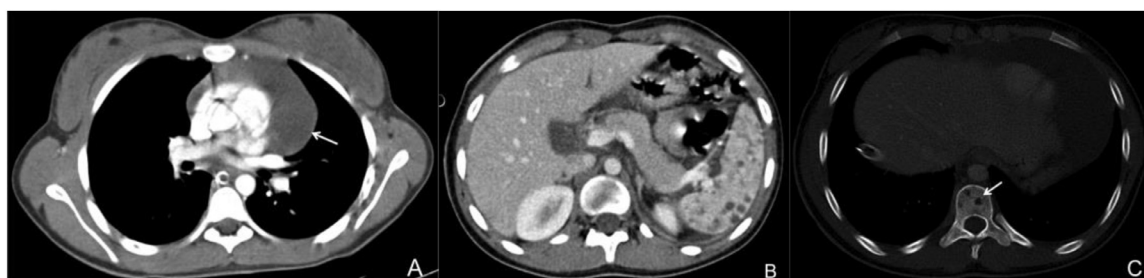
Contrast computed tomography in soft tissue window (A and B) demonstrating a cystic lesion in the anterior mediastinum (white arrow) without mass effect and multiple hypodense lesions in the spleen, none of the lesions showed enhancement with the contrast. computed tomography in bone window (C) where multiple lytic lesions (white arrow) in the vertebral bodies without associated soft tissue mass are shown.
